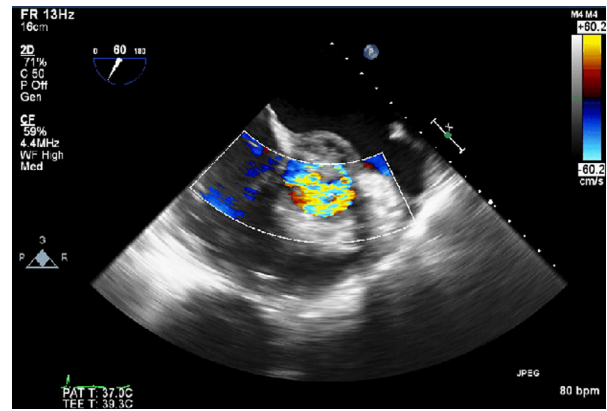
Midesophageal aortic valve short-axis transesophageal echocardiography color Doppler image obtained at end-diastole showing torrential aortic insufficiency.
